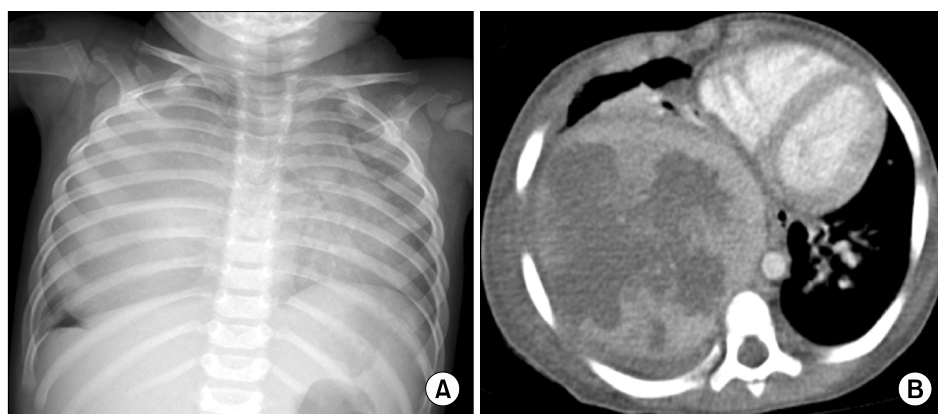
(A) Plain chest radiograph showing a homogenous opacity occupying the entire right hemithorax. (B) On a chest CT scan, there is a large mass in the right hemithorax that shifts the mediastinum to the left.
